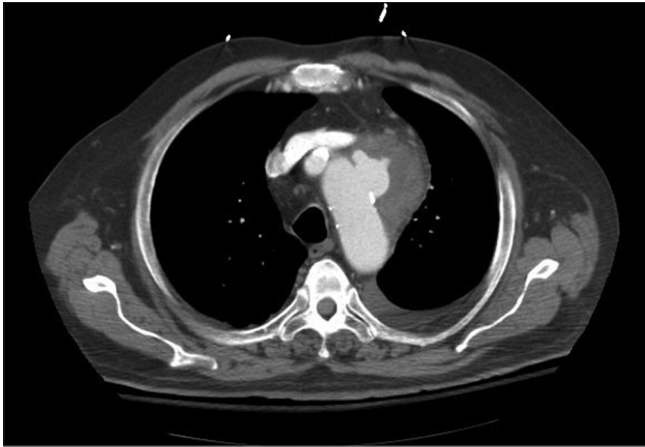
Axial computed tomography showing a contained rupture in the transverse aorta
